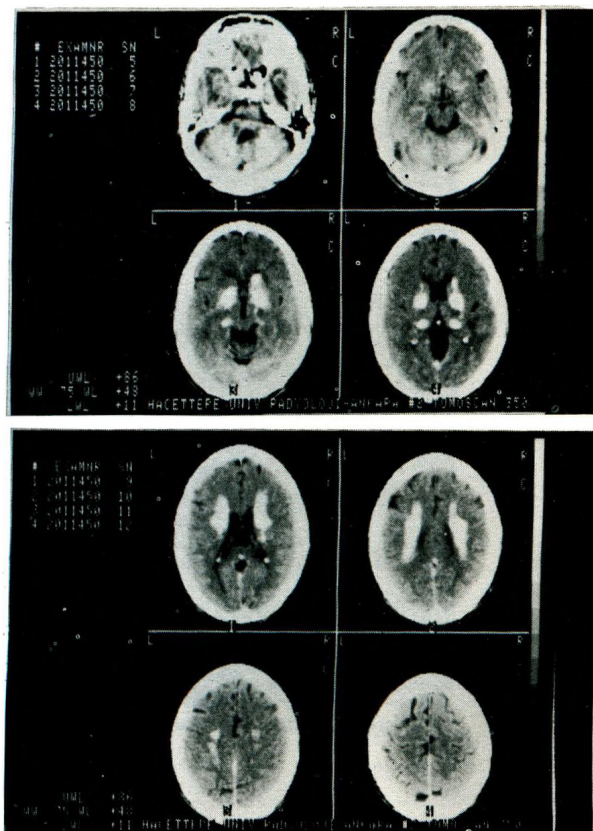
b: Axial CT-scans showing bilateral calcification in globus pallidus, caudate nucleus, thalamus, dentate nucleus and periventricular white matter.
